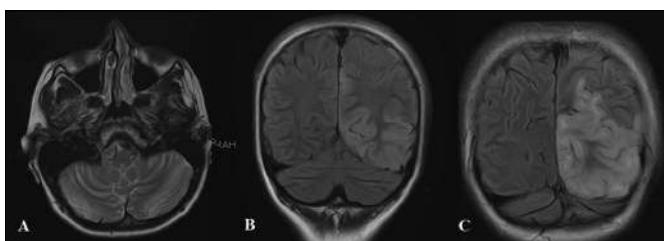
(A and B) Previously noted stroke like lesions in the cerebellar hemispheres had almost completely resolved on this examination (B and C) FLAIR images revealing gyral edema and subcortical involvement in the left parietal and occipital lobes.
